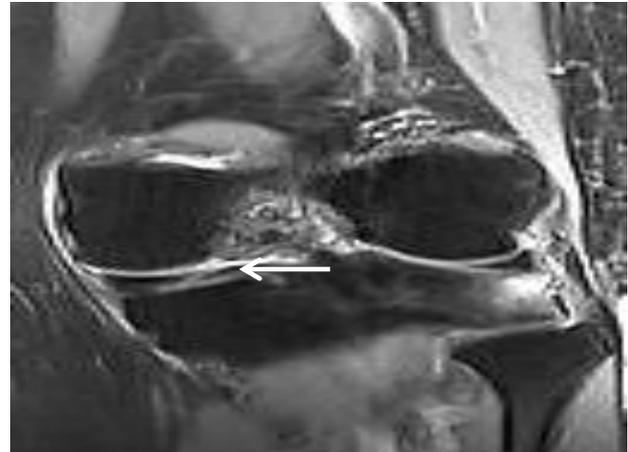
Radial tear in medial meniscus in a 50-year-old female. Coronal T2-weighted FSE fat-suppressed image shows a hyperintense signal involving the free edge of medial meniscus (arrow) and is perpendicular to the tibial plateau.
